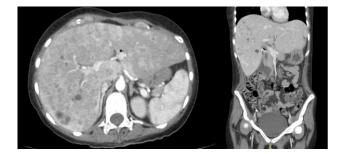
Simple and contrasted thoracoabdominal CT: cholangiolar abscesses; pneumobilia: surgical absences of gall bladder.
